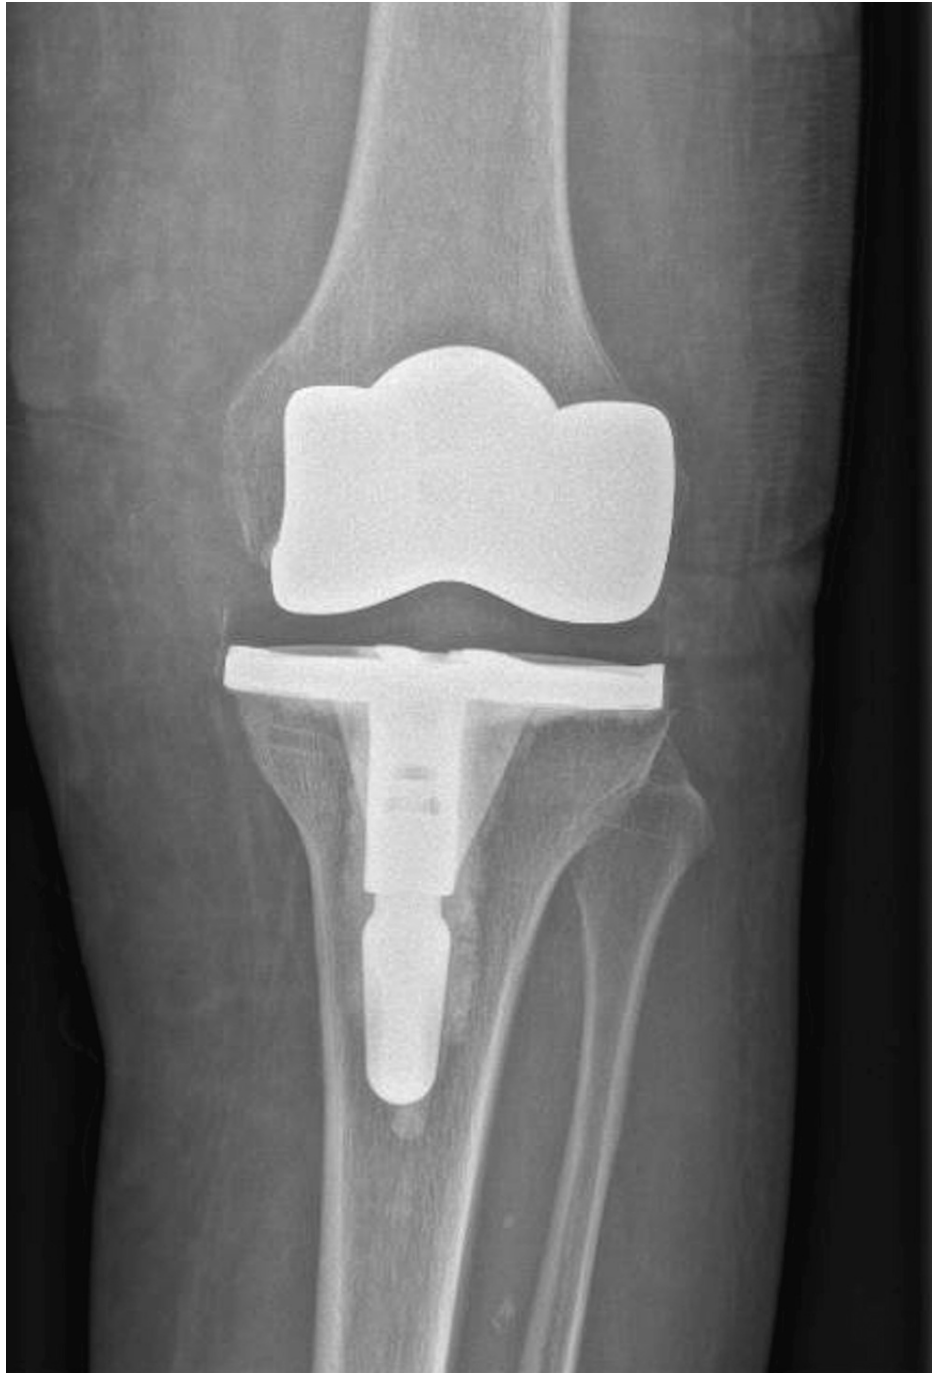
Postoperative X-ray (primary total knee arthroplasty) demonstrating the correct location of the implant.
